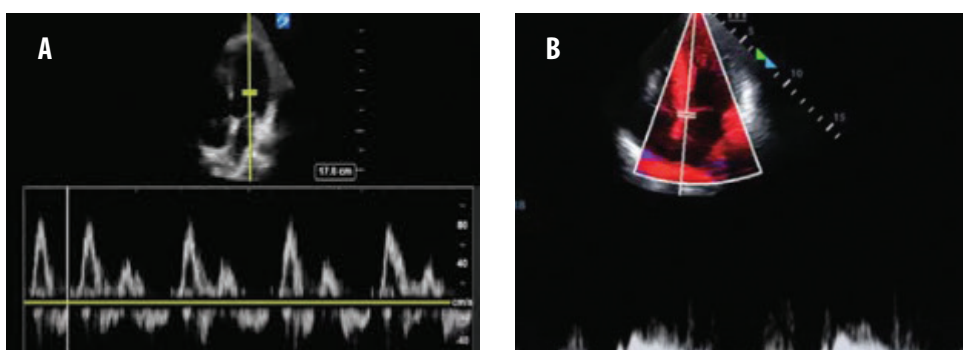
Transmitral Pulse Wave Doppler whit tracing of E and A waves (1A) and measurement of Septal e' with tissue doppler and Pulse wave Doppler (1B).
